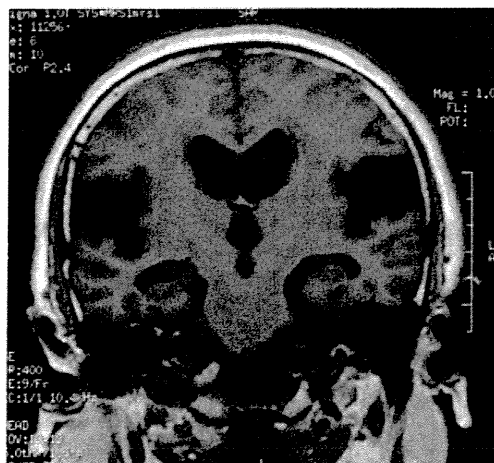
特発性正常圧水頭症患者の頭部 MRI (T1 強調画像)
